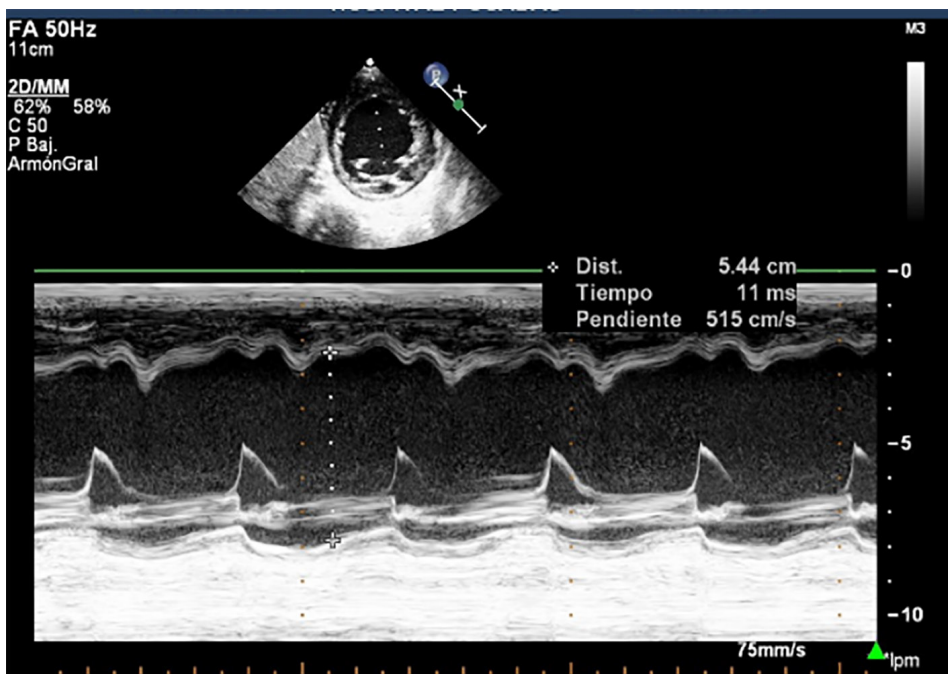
Transthoracic echocardiogram, parasternal short-axis view, M-mode, showing left ventricular dilation and septal dyskinesia.
